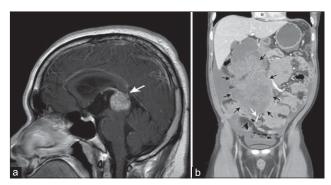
(a) A contrast-enhanced brain magnetic resonance imaging image shows a mass lesion (arrow) in the pineal region with compression to the third ventricle above the cerebral aqueduct. It causes obstructive hydrocephalus at bilateral and third ventricles. (b) A contrast-enhanced coronal abdominal computed tomography image shows multiple well-defined heterogeneous and homogeneous mass lesions in the omentum and mesentery (black arrows). A ventriculoperitoneal shunt (white arrow) located close to the mass lesions
